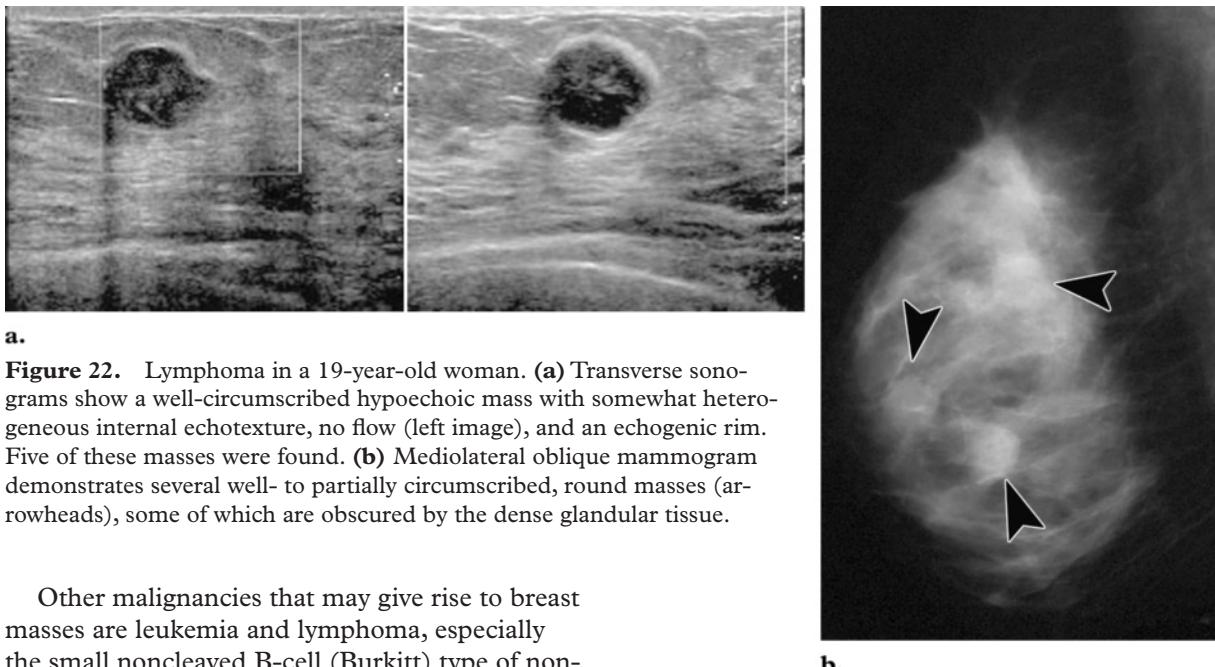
Lymphoma in a 19-year-old woman. (a) Transverse sonograms show a well-circumscribed hypoechoic mass with somewhat heterogeneous internal echotexture, no flow (left image), and an echogenic rim. Five of these masses were found. (b) Mediolateral oblique mammogram demonstrates several well- to partially circumscribed, round masses (arrowheads), some of which are obscured by the dense glandular tissue.
